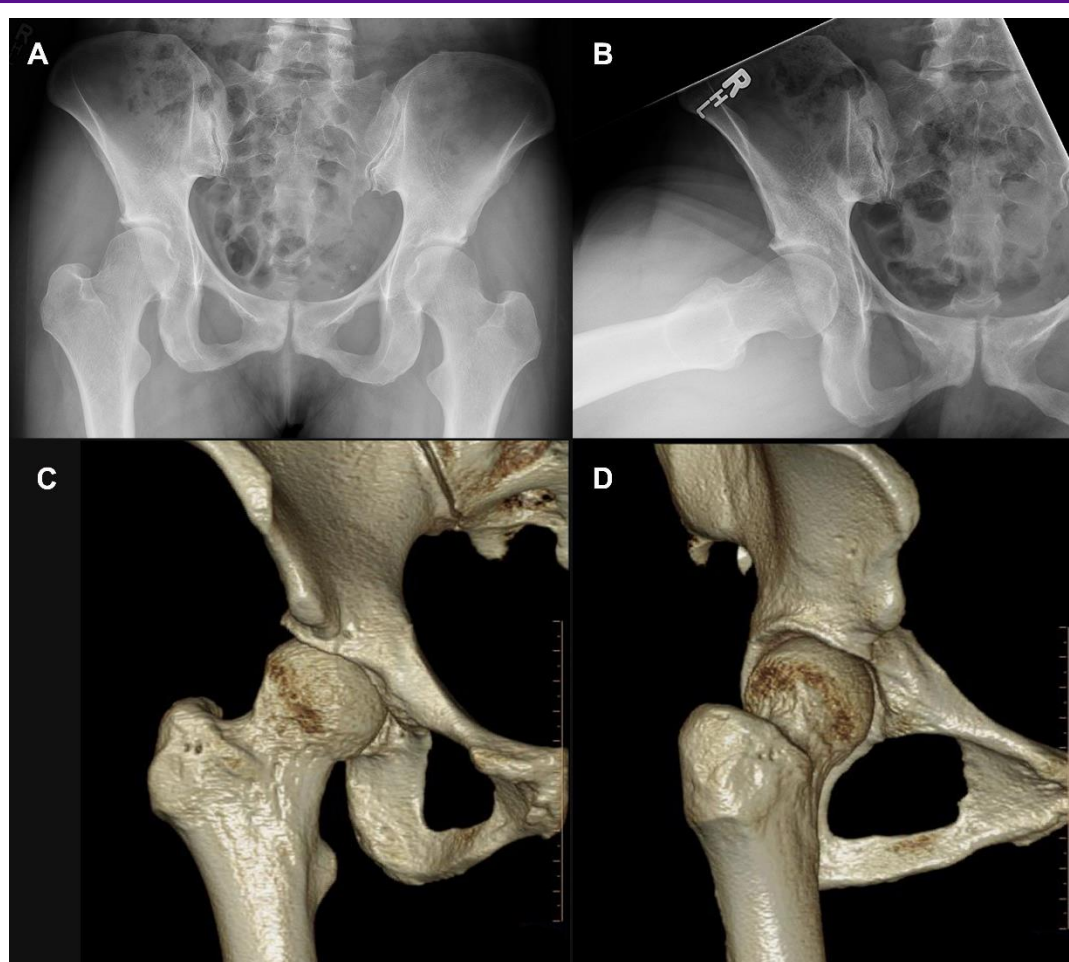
Comparison of plain radiograph and 3D CT characterization of bony deformity in a case of femoroacetabular impingement. (A) Plain radiograph AP pelvis; (B) Elongated-neck lateral radiograph in position of 90° hip flexion; (C) CT hip with multiplanar reformatting, anteroposterior view of pelvis and femoral head-neck junction; (D) CT hip with multiplanar reformatting, anterolateral view of pelvis and femoral head-neck junction.
